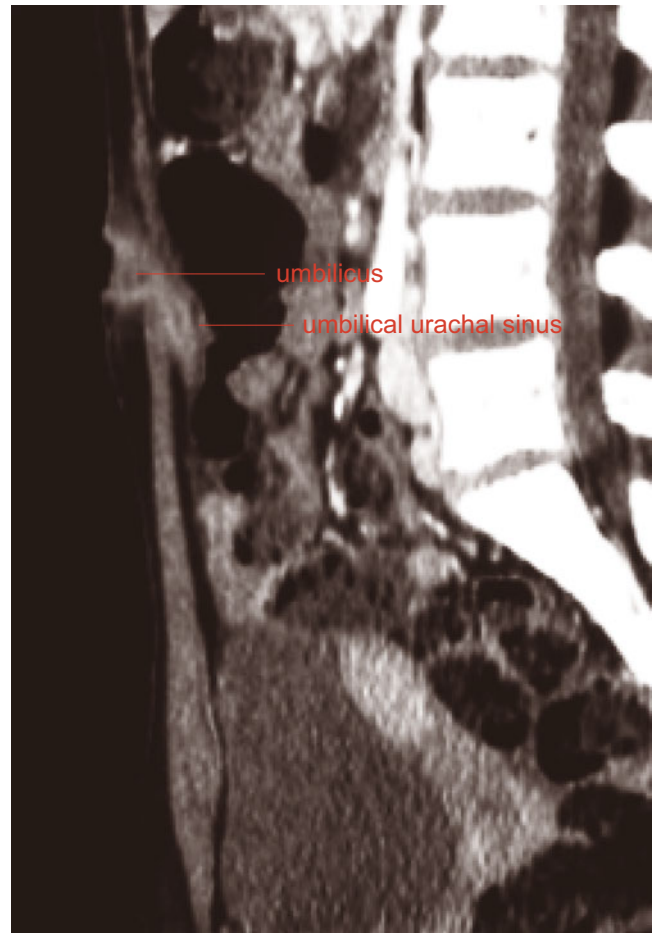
Umbilical urachal sinus: CT scan. Demonstration of the blind-ending tubular structure from the umbilicus
